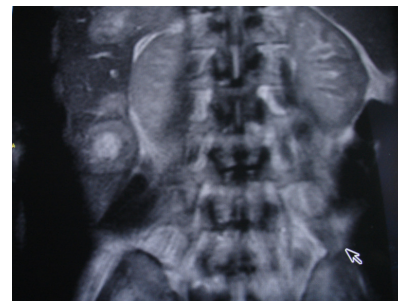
Coronal T2W MRI- liver metastases showing heterogeneous signal intensity with central hyperintense and peripheral isointense areas.
